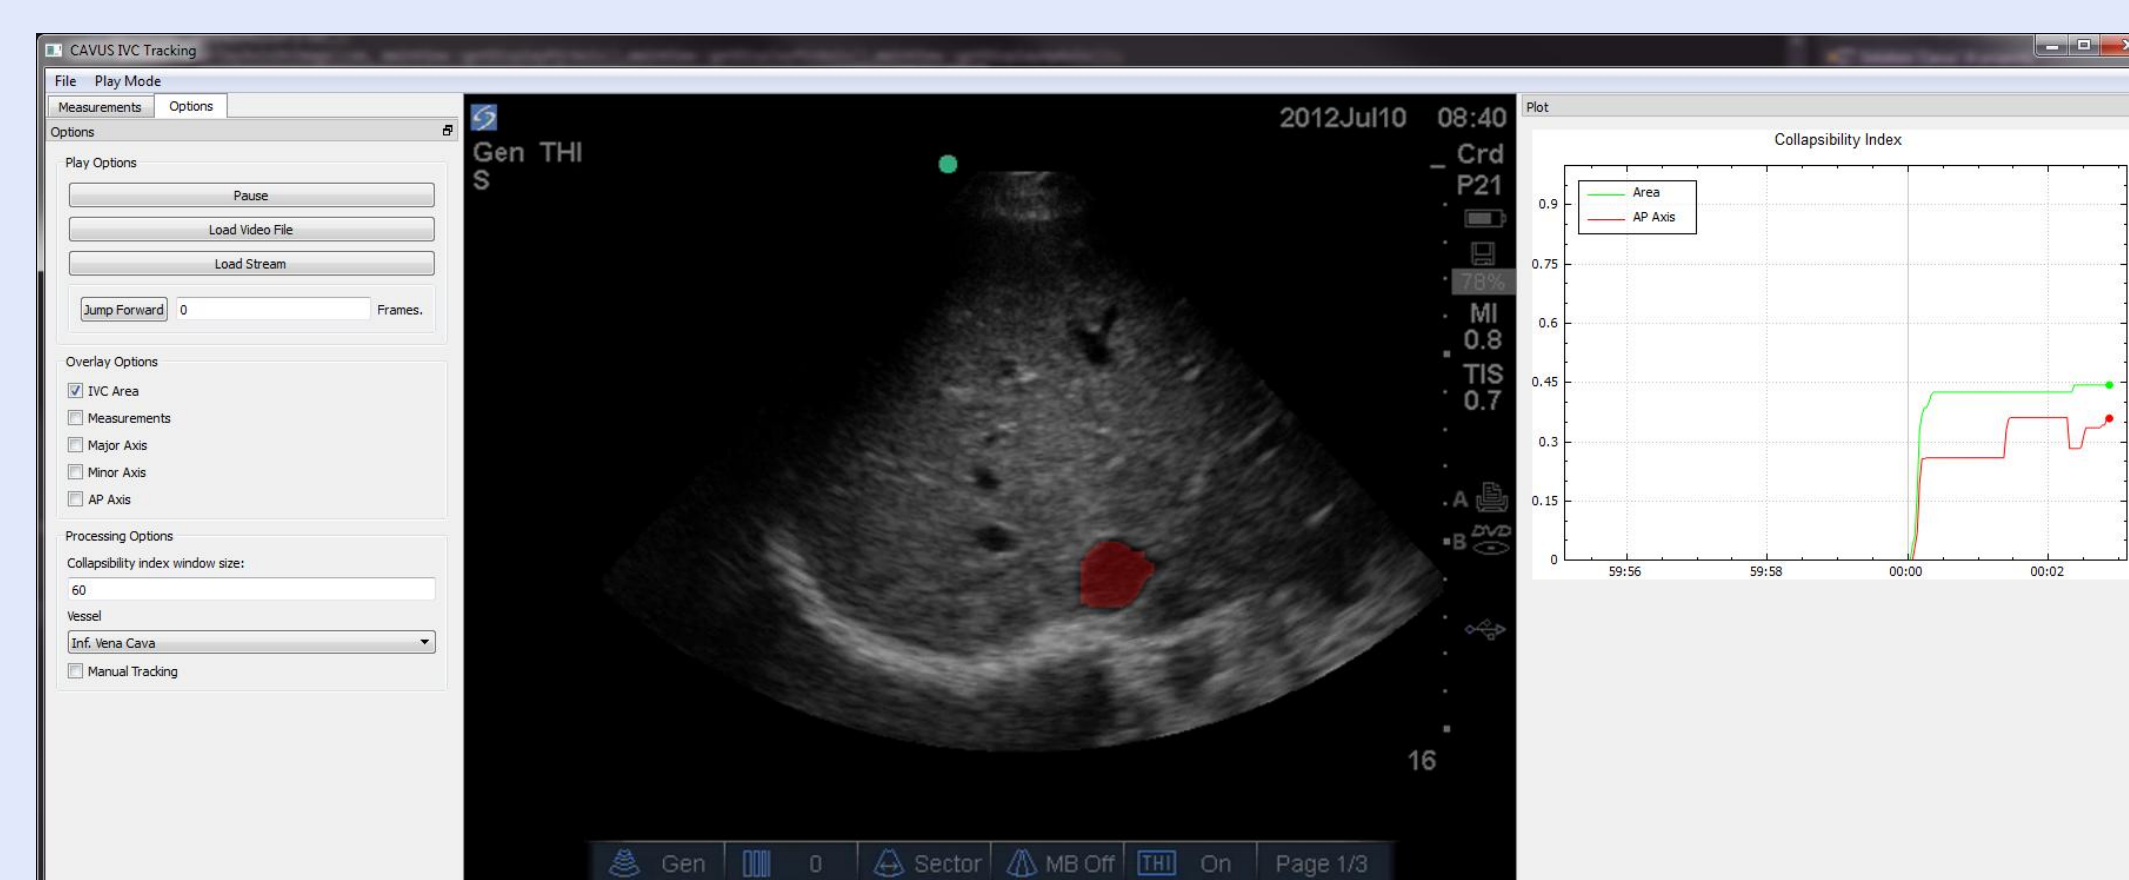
Software providing real-time blood vessel segmentation, volume estimate and collapsibility index from ultrasound
